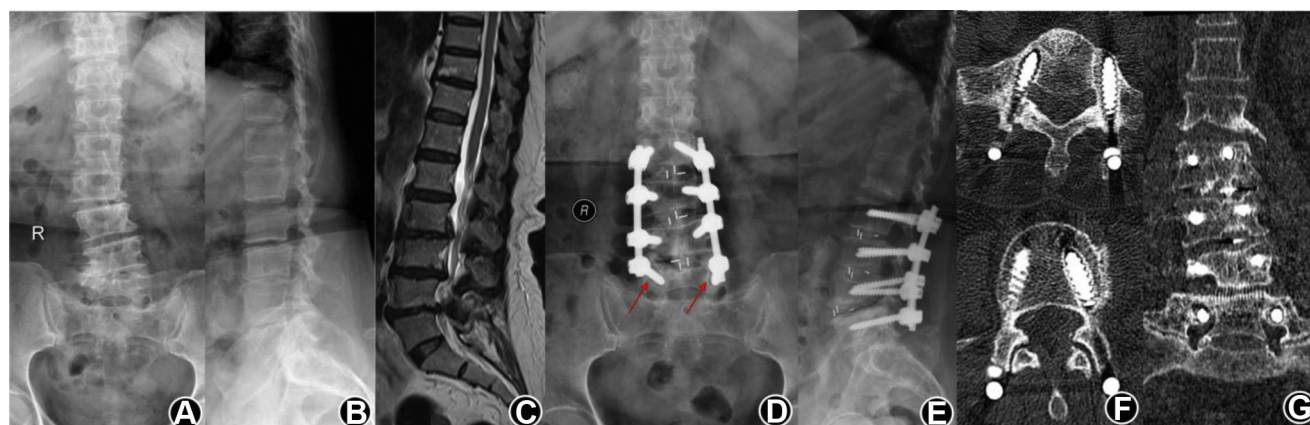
Female, 73-years-old, T= -2.6 SD (A, B). Preoperative X-rays showed degenerative changes and scoliosis in lumbar spine (C). Preoperative MRI showed L2-5 level lumbar disk herniation with spinal canal stenosis (D, E). The lumbar radiographs of 6 months after surgery showed
